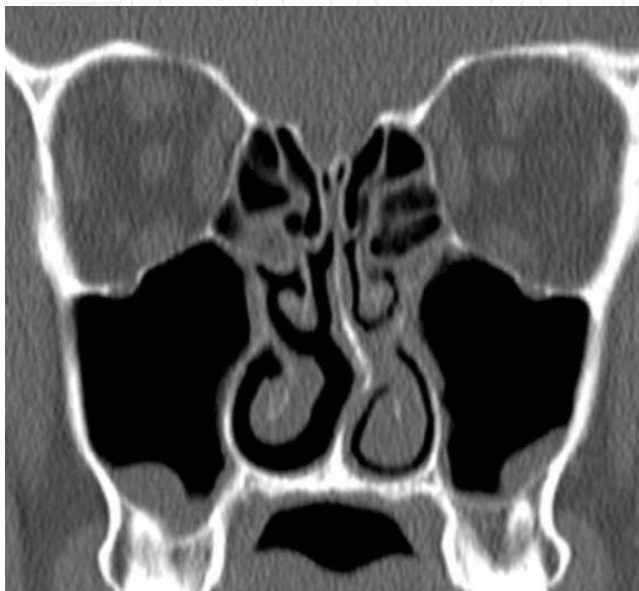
(a) Coronal CT shows a retention cysts and sparse mucosal thickening classified as a sporadic inflammatory pattern.
